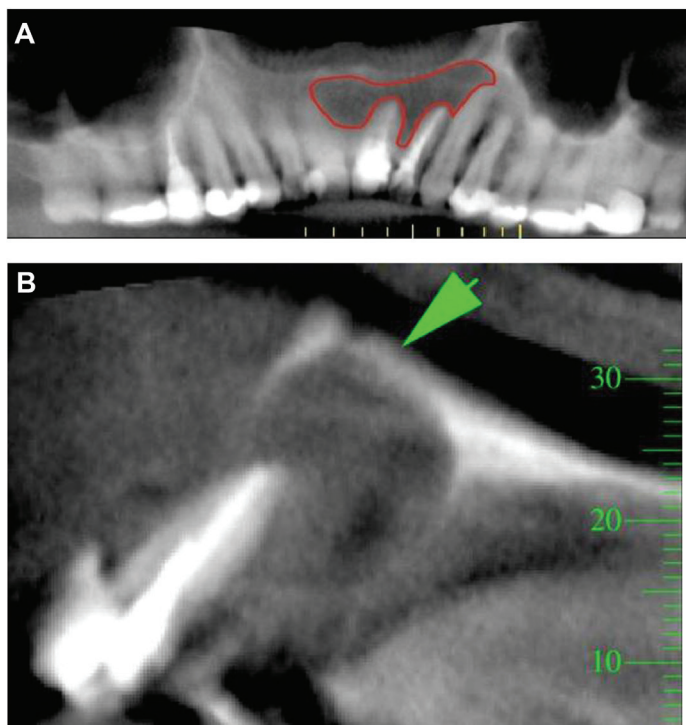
A. Panoramic radiographic showing demarcated radiolucent area. B. CT scan in sagittal view showing the cyst and the nasal cavity floor just above (arrow), with a small fistula.
